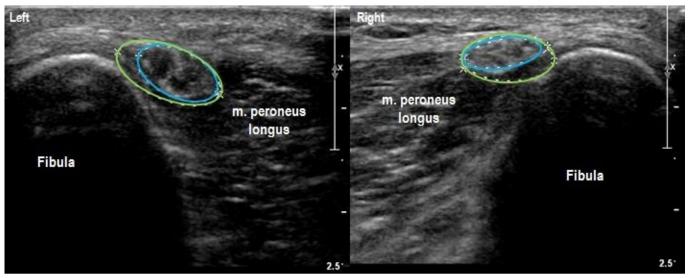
Ultrasound case 3: The left *n. fibularis communis* appears hypoechoic in comparison to the contralateral side.
